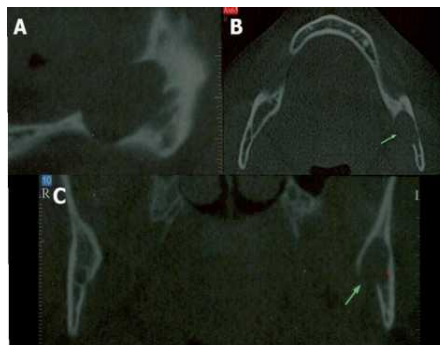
CT sects showing hypodense, unilocular image with cystic aspect, causing cortical rupture. longitudinal (A), axial (B) and coronal (C) slices
